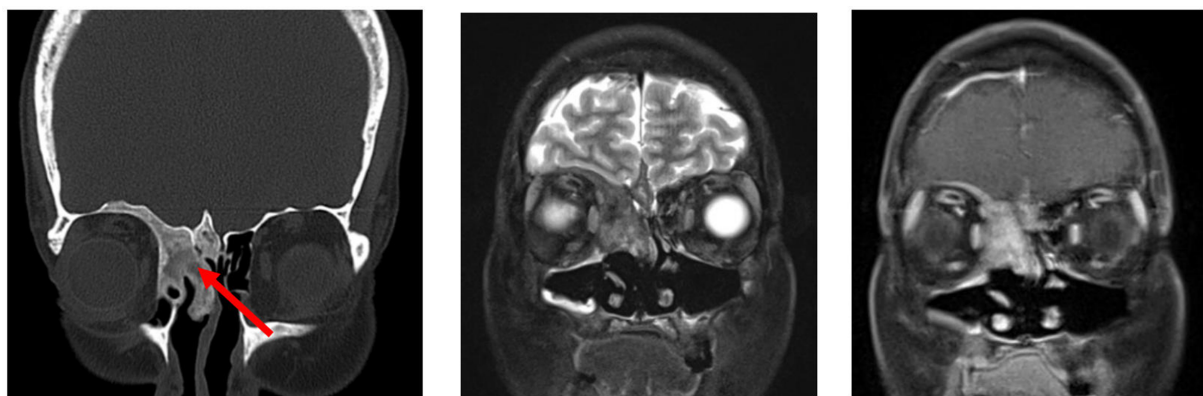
Coronal CT and MR images (left to right: T2 and post-contrast T1) of fibrous dysplasia showing the characteristic ground-glass matrix on CT (arrow). CT: Computed tomography; MR: magnetic resonance.
